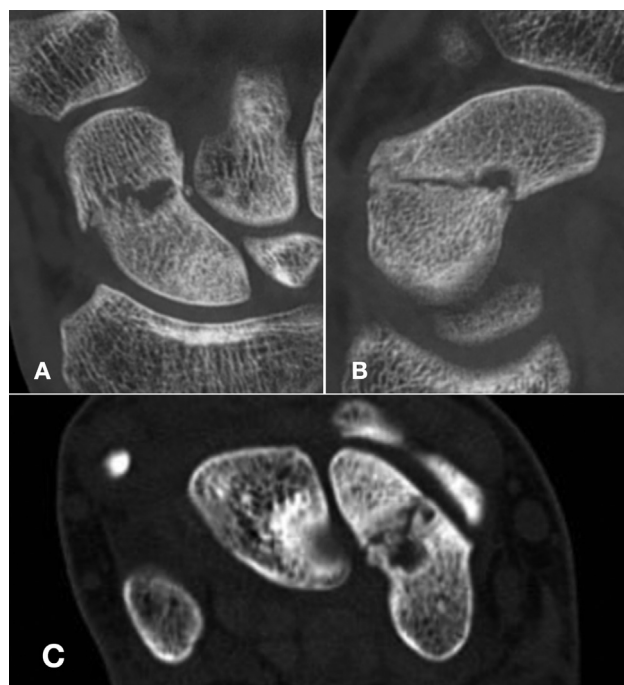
Preoperative computed tomography delayed scaphoid consolidation in a 32-year-old patient with a history of right wrist trauma while playing hockey 12 weeks ago. Note the edge resorption, the cysts < 5 mm, and the focal displacement < 1 mm. A, Coronal image. B, Sagittal image. C, Axial image.
